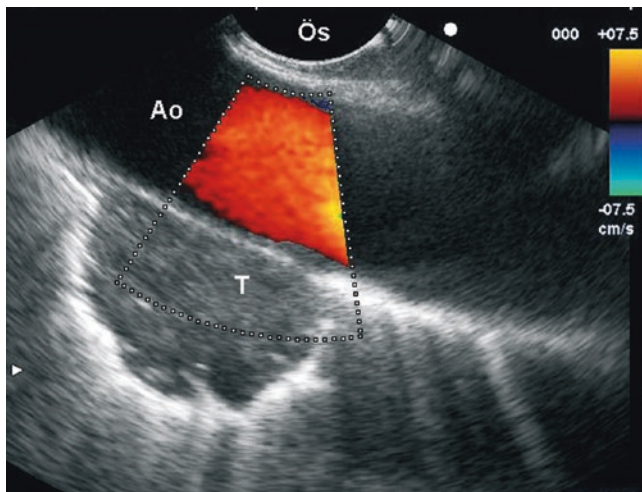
Endosonography. Lung tumor (T) located in the left upper lobe with a close relation to the aorta (Ao). There are no signs of tumor invasion (T4) in the aorta. Ös esophagus
